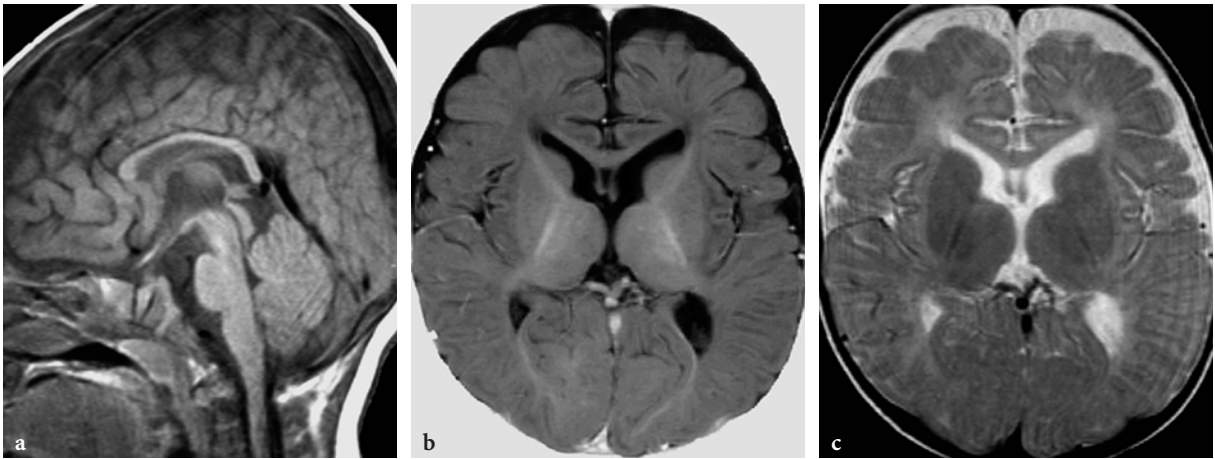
Conventional MR imaging findings in type IV mucopolipidosis in a 3-year-old male patient. a Sagittal T1-weighted spin-echo image shows hypotrophy or hypoplasia of corpus callosum. b Axial T1-weighted inversion recovery image. Poor myelination throughout both cerebral hemispheres; peripherally, practically no myelin is seen. c Axial T2-weighted fast spin-echo image. Extensive white matter signal abnormalities, probably representing combination of delayed and hypomyelination
